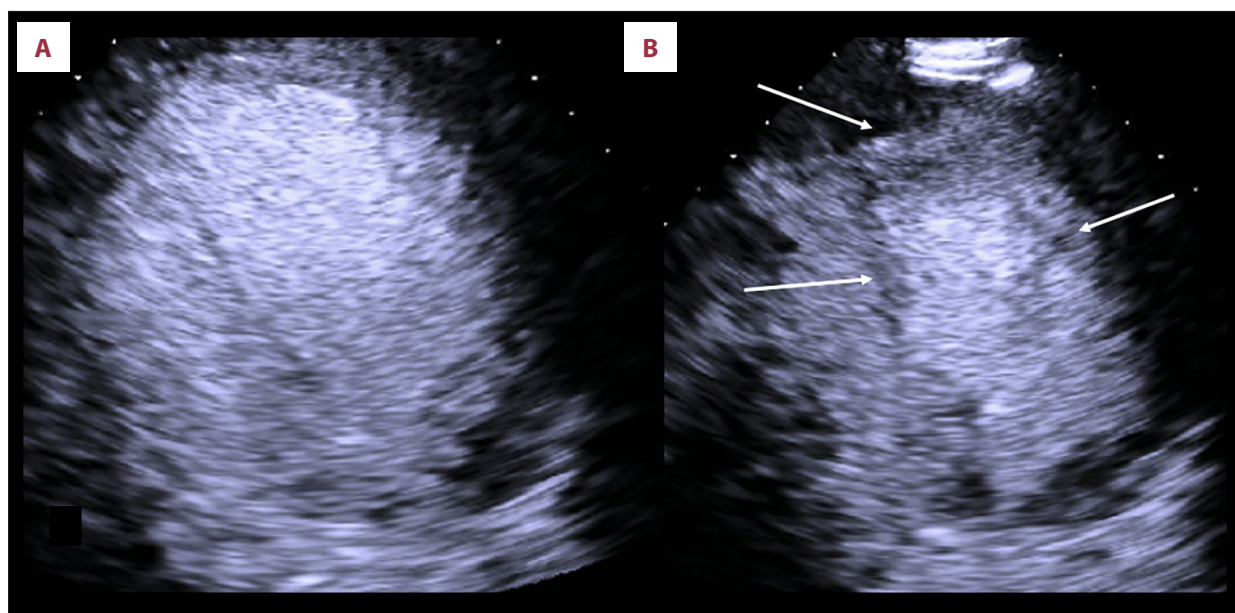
Takotsubo cardiomyopathy event in 2023: transthoracic echocardiogram with apical 4-chamber view; diastole (A), systole (B). Circumferential, mid-distal hypokinesis is shown, excluding the apical segment. Arrows demonstrate akinetic anterolateral and inferoseptal walls with a contractile apex.
